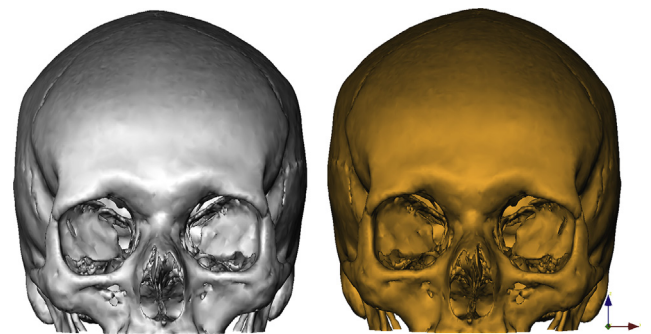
Automatically created original (white colored) and mirrored (orange colored) 3D virtual hard-tissue model in Maxilim (version 2.3.0; Medicim NV, Mechelen, Belgium) after CT data (in DICOM format) has been imported.
